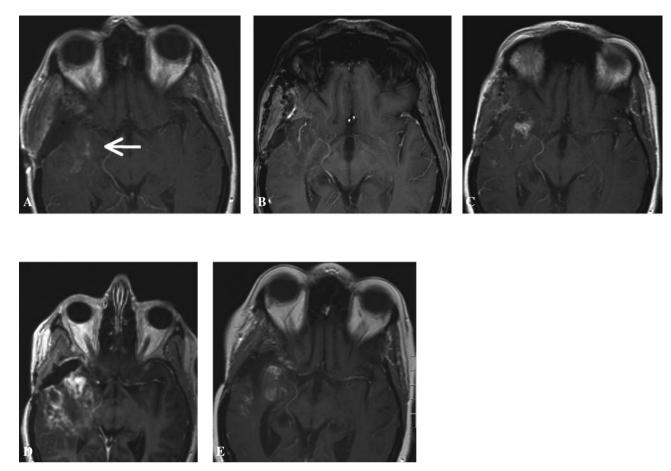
Tumor regression following first line temozolomide and, in the further course of disease, third line CCNU treatment. Following an inaugural epileptic seizure, this female patient was diagnosed at the age of 34 year with a right sided temporo-frontal non-gadolinium enhancing tumor mass. A complete resection was performed. An anaplastic oligo-astrocytoma without loss of chromosomal arms 1p or 19q was diagnosed. Postoperative radiation therapy was administered at a dose of 60 Gy. In February 2007, 4.5 years following the initial diagnosis, tumor recurrence was treated by surgery. Resection was complete except for infiltrating temporal extension (partial resection, (A, axial plane Gd enhanced T1 MRI imaging)) and followed by temozolomide chemotherapy (5 out of 28 days at a dose of 200 mg/m²/day). A complete radiologic response was obtained after 3 cycles of temozolomide (B) and she remained progression-free for 6 months. At progression (C), the patient was subsequently treated in a phase II protocol but did not benefit from the experimental treatment (D, axial and sagittal plane images from Gd enhanced T1 MRI imaging). As third-line therapy for recurrent disease she received lomustine (CCNU) at a dose of 110 mg/m², once every 6 weeks, and responded to this therapy (E) for 4 months.
